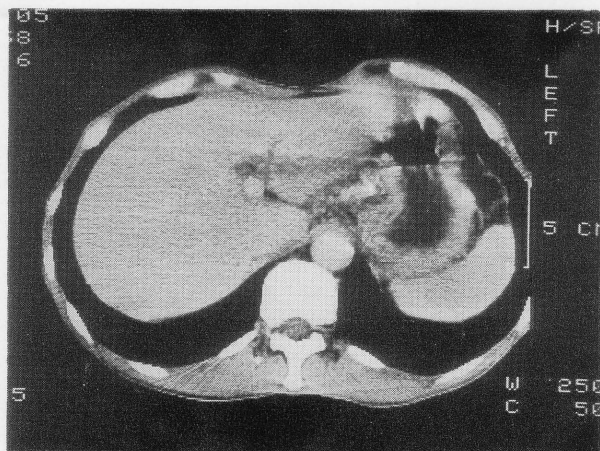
No mass was depicted in the liver by thoracic CT.
